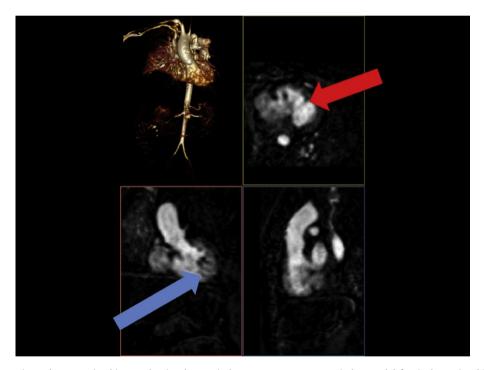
MRI 3D reconstruction and cross-sectional images showing the ventricular mass arrangement, ventricular septal defect (red arrow) and RV apex (blue arrow).
